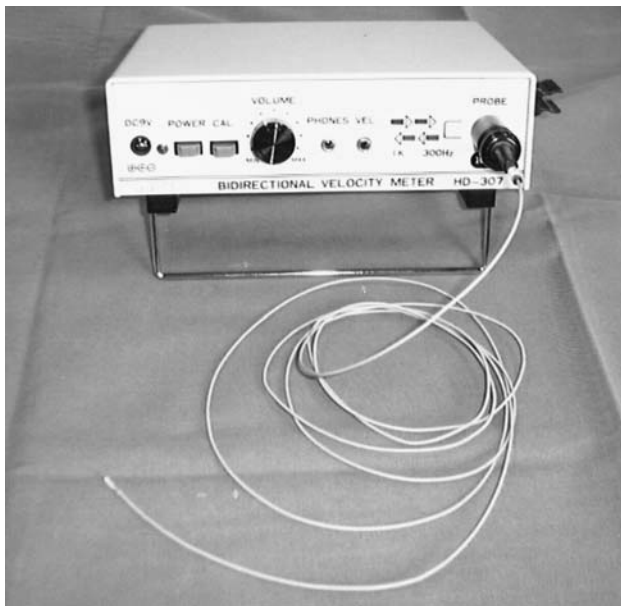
A The ultrasonic two-way Doppler flow detector incorporated with a minute probe tip with a diameter of 2 mm. B Marking the position for arterial puncture using an office clip and the flow detector
